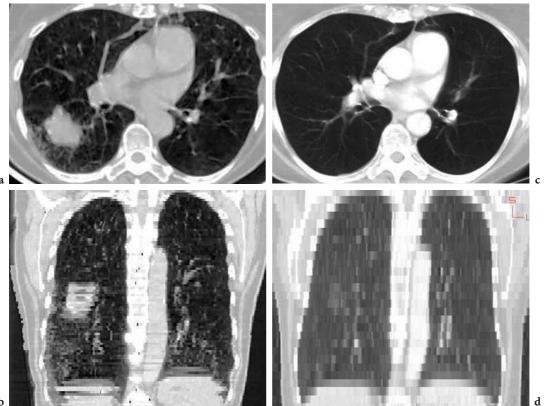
CT images showing lung tumor before and after treatment. a, b Pretreatment. c, d Six months after proton therapy
